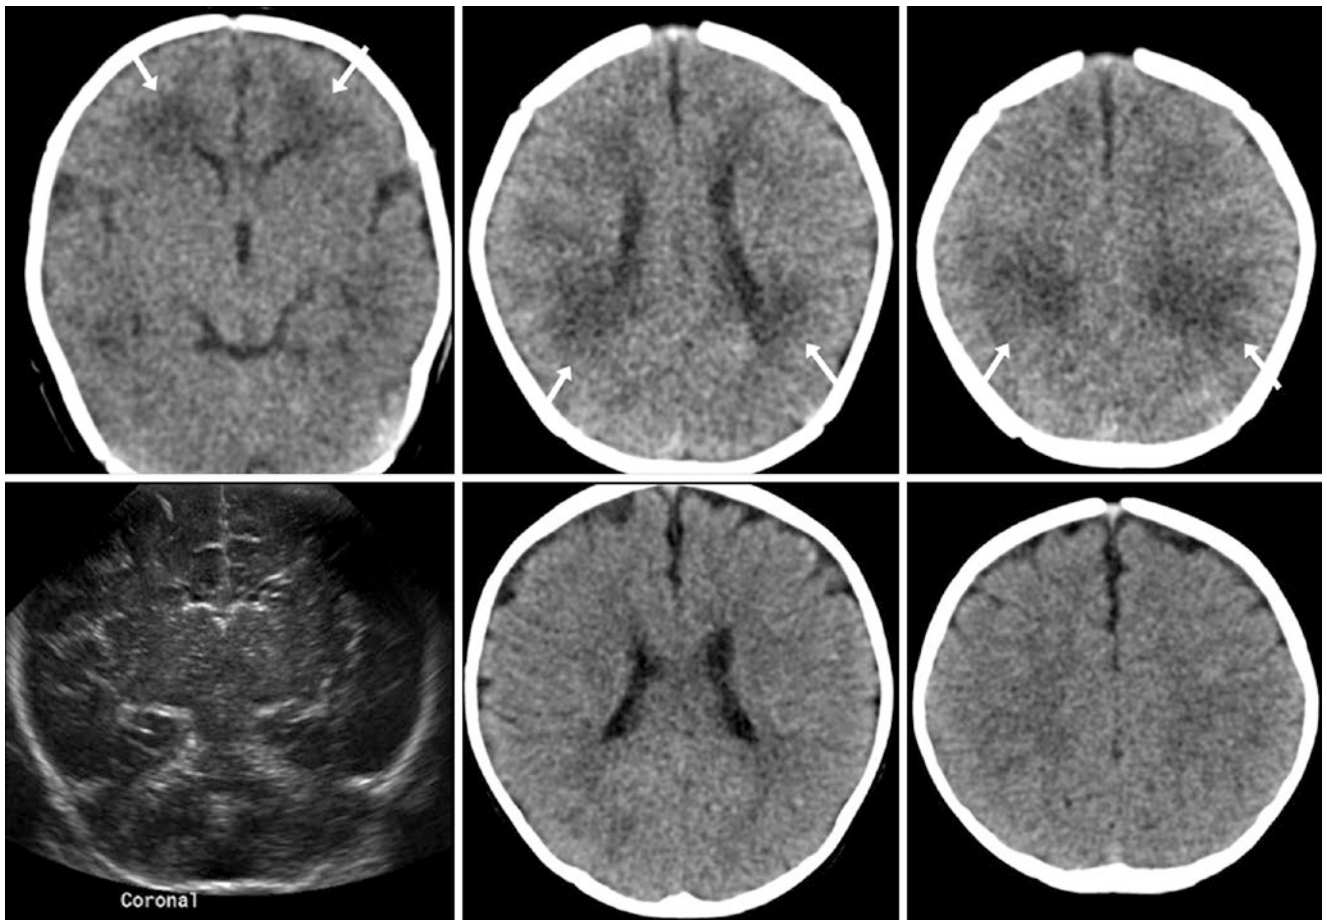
A 4-day-old term neonate with a possible hypoxic event had an otherwise negative NECT (*top row*), which showed scattered, patchy regions of hypoattenuation throughout the PVWM (*arrows*). A coronal ultrasound (*bottom left*) was also called negative. Note the intact overlying
